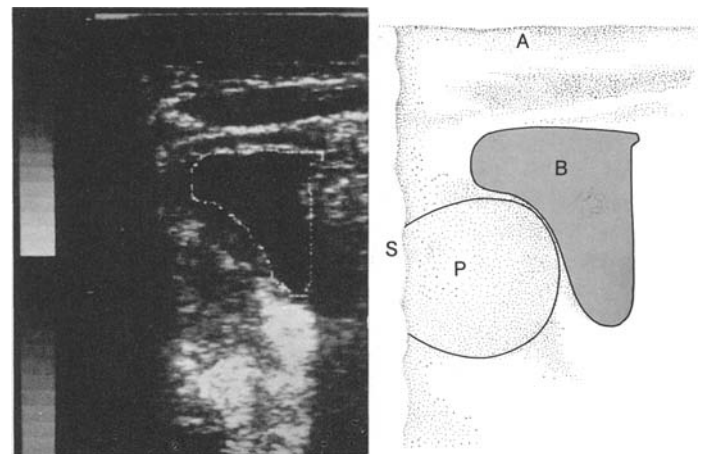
Ultrasonic examination of urinary bladder. Prostatic hyperplasia. Sagittal section. (S: Shadow of pubic bone, A: Abdominal wall, B: Urinary bladder, P: Prostate)
